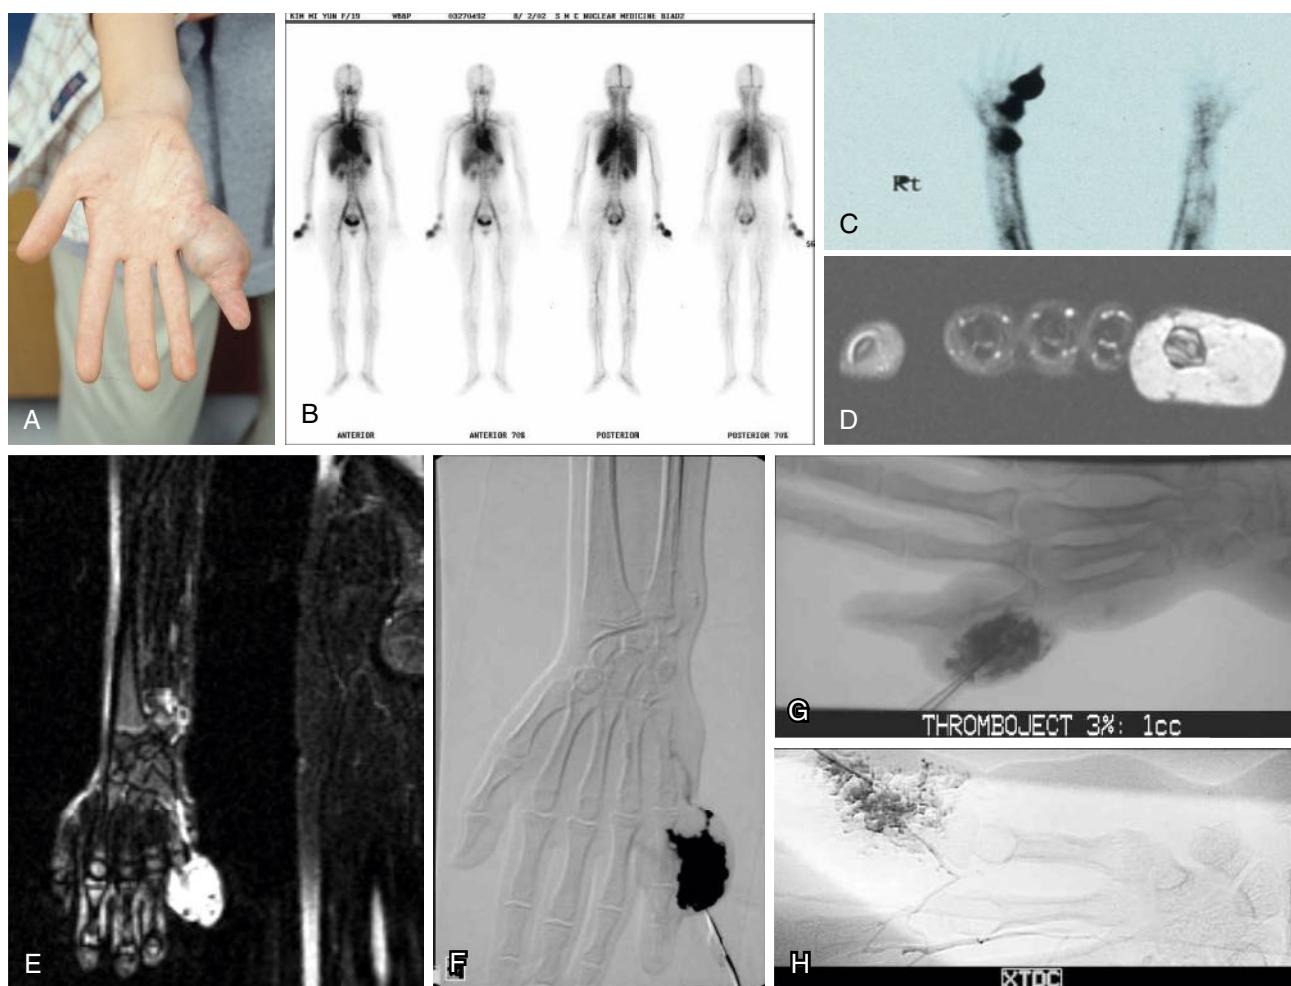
Endovascular Sclerotherapy with Sodium Tetradecyl Sulfate. (A) Localized venous malformation affecting the entire right fifth finger and extending to the palm. (B, C) Whole-body blood pool scintigraphy displays intense abnormal blood pooling of a much larger magnitude than is evident clinically. (D, E) MRI demonstrates a similar condition within close proximity to the skin. This finding suggests a higher risk of necrosis if ethanol is used. (F–H) Based on percutaneous direct-puncture phlebography findings (F), 3% sodium tetradecyl sulfate was used as a sclerosing agent (G), with an excellent response (H). Despite repeated sessions, the skin did not slough.
